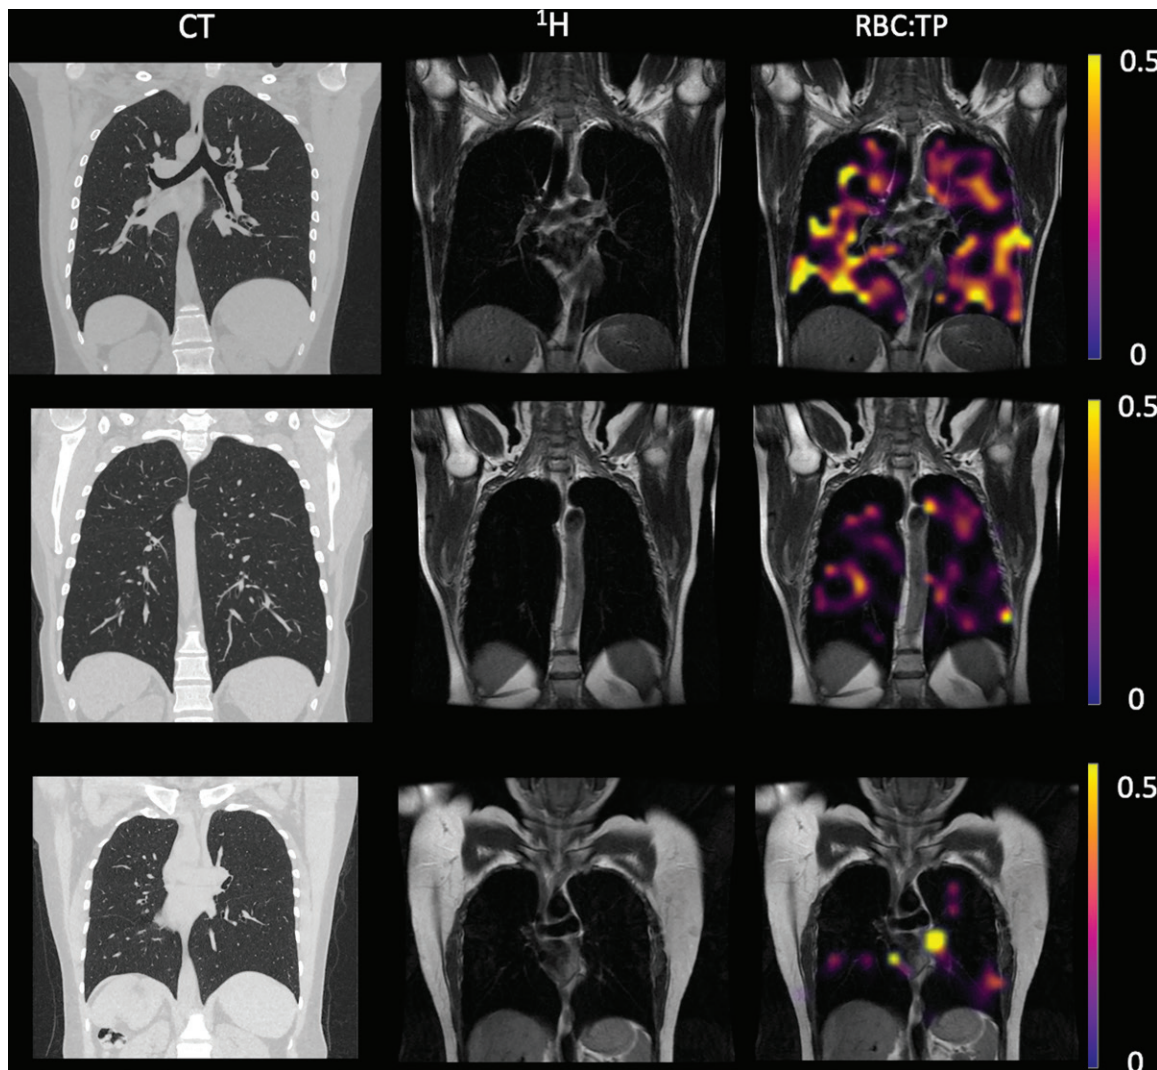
Example CT, proton (^1H), and proton and red blood cell-to-tissue plasma (RBC:TP) images in participants with post-COVID-19 condition. Top row: Images in a participant with an RBC:TP value of 0.49. Middle row: Images in a participant with an RBC:TP value of 0.31. Bottom row: Images in a participant with an RBC:TP value of 0.24. Imaging revealed little to no discernible damage on CT scans, yet highly heterogeneous and low RBC:TP values in the lungs of nonhospitalized participants with post-COVID-19 condition.
